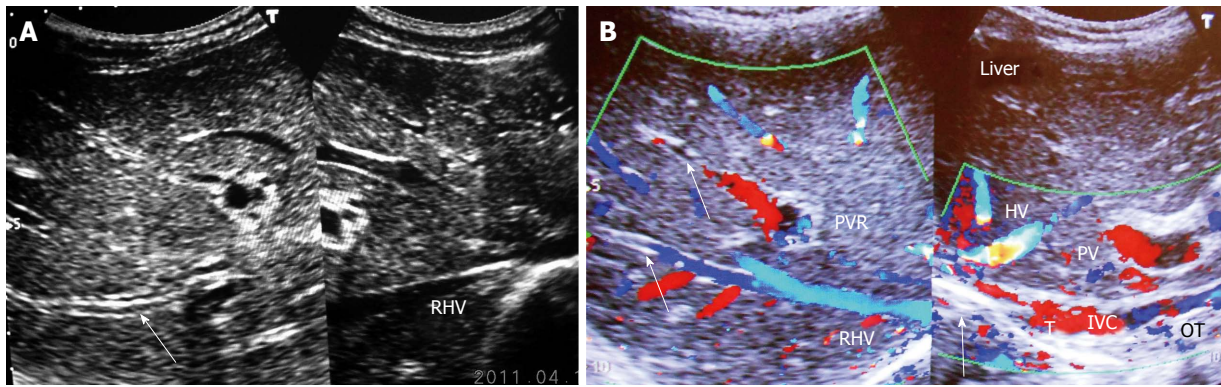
Ultrasonography showing thrombosed intra-hepatic veins. A: Ultrasonography showing diffuse thrombosed and echoic walls of large and medium-sized intra-hepatic veins (one of which is indicated by an arrow) that occurred during acute exacerbation. Right hepatic vein (RHV) orifice is narrowed; B: Color Doppler Ultrasonography of patient with cirrhosis. It shows long segment stenosis of inferior vena cava (IVC) with recent thrombus (T) and old organized thrombi (OT) on thick posterior wall. Arrow shows thrombosed large and medium-sized intra-hepatic veins. HV: Hepatic vein; PV: Portal vein; PVR: Portal vein radical.
